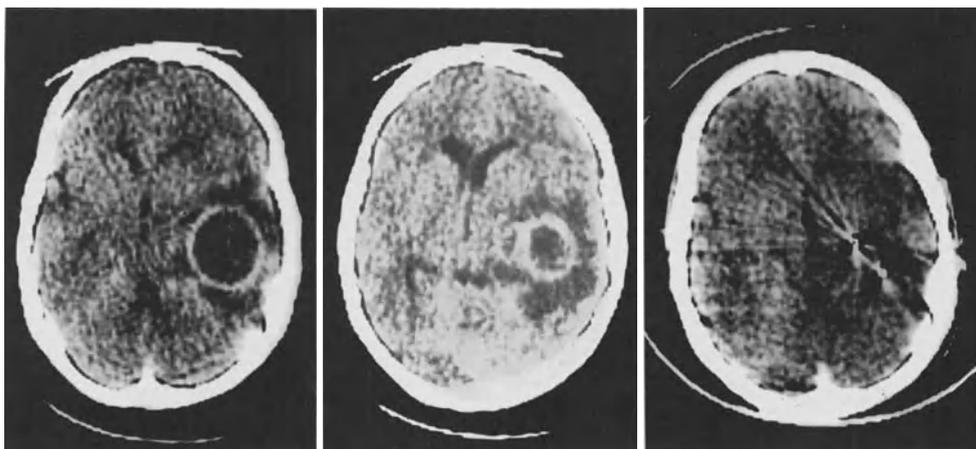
Patient No. 4 from Table 2 CT-scan, brain abscess temporal. *Left:* preoperative; *middle:* post-aspiration; *right:* post-excision
